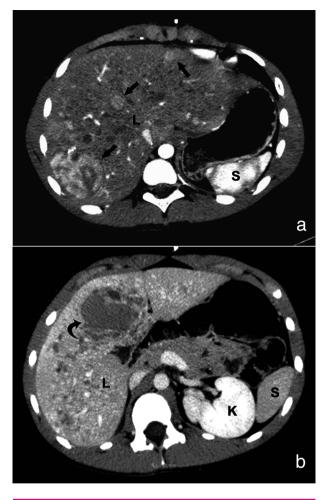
Patient #2 ten days prior to BMT, presenting with abnormal liver function tests. Contrast enhanced abdominal CT at an arterial phase (a) demonstrates multiple hypervascular hepatic lesions (arrows). An additional image at a lower level (b) demonstrates a large hypodense hepatic lesion (curved arrow). Similar smaller lesions are dispersed throughout the liver. L=liver; S=spleen; K= kidney.
